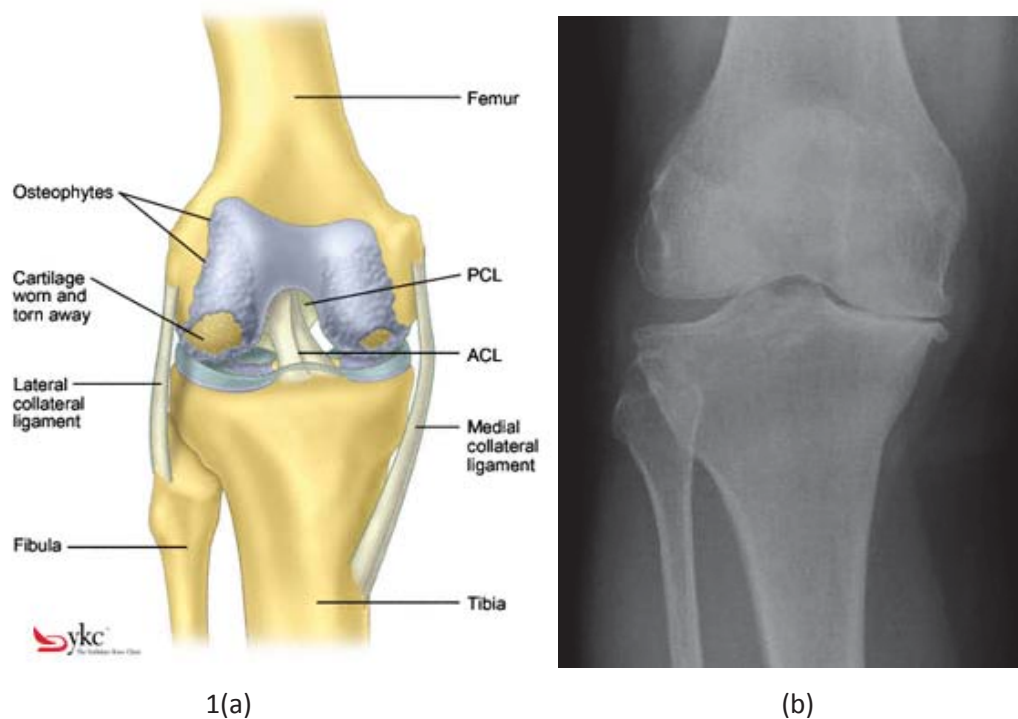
Progressed osteoarthritis of the knee. (a) Representation of the knee, where the cartilage at the joint has been worn and torn away. (b) X-Ray of severe osteoarthritis- the cartilage shielding the tibia from the femur has been eroded, so the bones are now in contact. Images from Yorkshire Knee Clinic.
